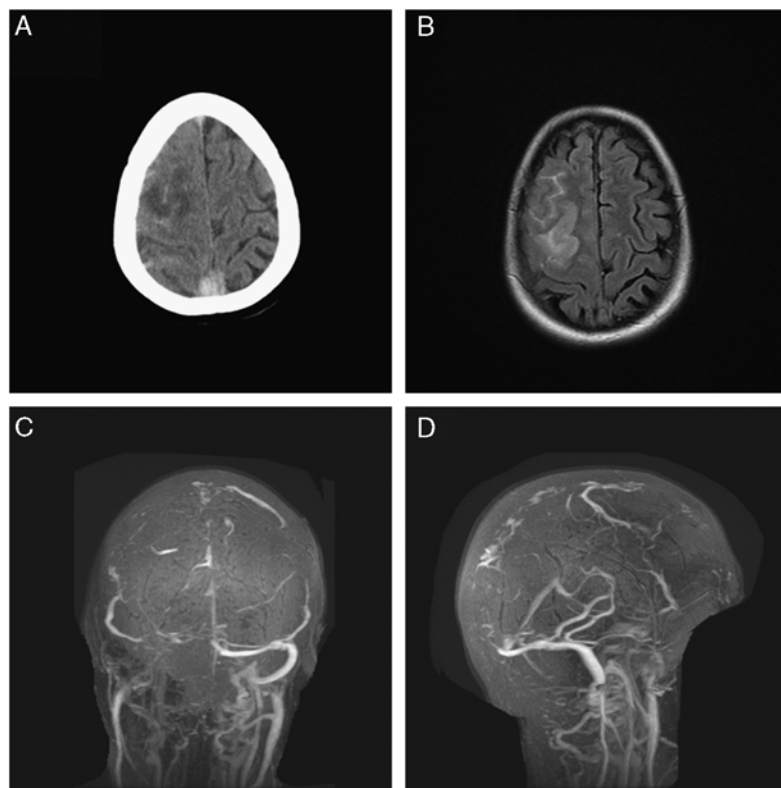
Extensive cerebral venous sinus thrombosis. Noncontrast CT demonstrating sagittal sinus hyperdensity and right frontal hypodensity (A). FLAIR MRI shows hyperintensity involving right frontal cortex (B). MRV reveals occlusion of the superior sagittal sinus, right transverse, sigmoid, and jugular vein (C, D), indicative of extensive venous thrombosis.
